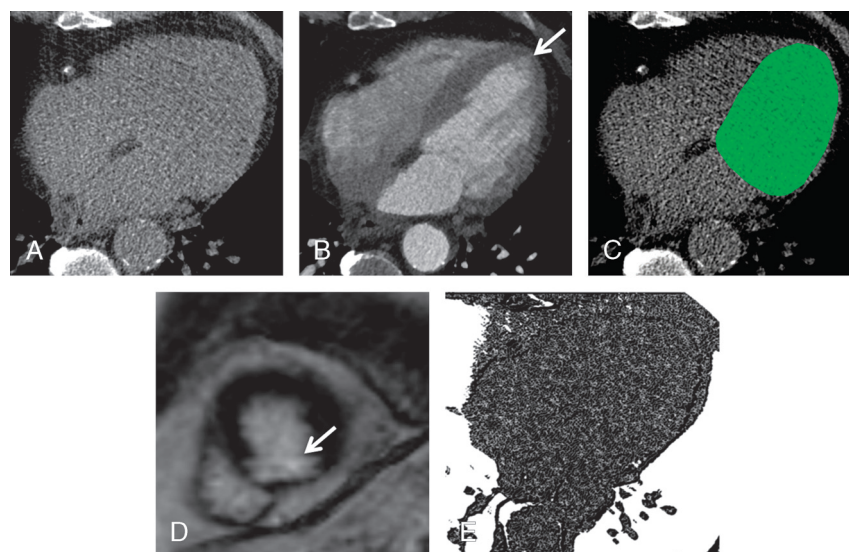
A and B, Axial CCT images of a 61-year-old male patient with chronic myocardial infarction. A, The non-contrast-enhanced image shows no abnormalities, the infarct cannot be seen. B, The contrast-enhanced image shows thinning of the left inferior apex (arrow), consistent with chronic scar. C, Free-hand region of interest delineation (green) for texture analysis (TA) of the left ventricle including the blood pool on the non-contrast-enhanced CCT image. D, Diagnosis was confirmed in short-axis cardiac MR image showing late gadolinium enhancement of the inferior apical myocardium (arrow). E, Parametric map of texture feature GLCM S5,-5 InvDfMom, which differed significantly between controls and patients with MI.
